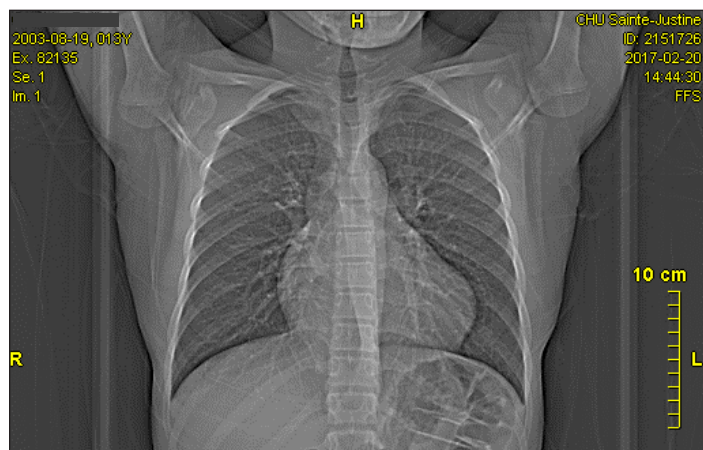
Reconstruction pulmonary CT: presence of little calcified nodules
